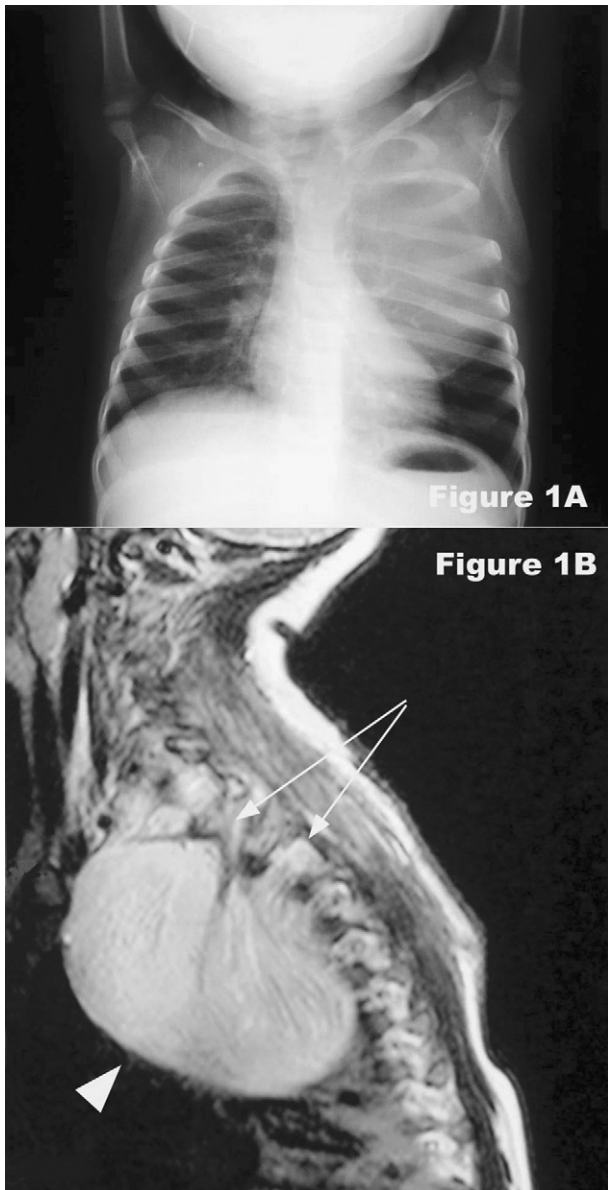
(A) Chest X-ray showing the mass within the left hemithorax. (B) T-2 weighted magnetic resonance image in sagittal sections showing the mediastinal tumor (arrowhead) with its intervertebral involvements (arrows).
